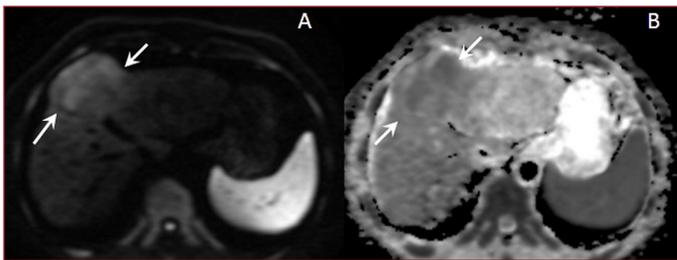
HCC case observed to have hypo-, hyper-, and isointense areas with heterogeneous intensity in both A) DWI; B) ADC map
